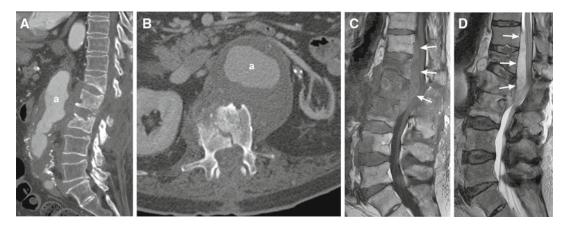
Imaging findings associated with spondylodiscitis. An 85-year-old man presents from another institution with progressive back pain and a history of an aortic graft. A sagittal CT image (\mathbf{A}) shows multilevel spondylodiscitis with pathologic vertebral fractures in direct continuity with a supragraft aortic pseudoaneurysm (a) which is also seen on the axial image (\mathbf{B}). Sagittal T1
